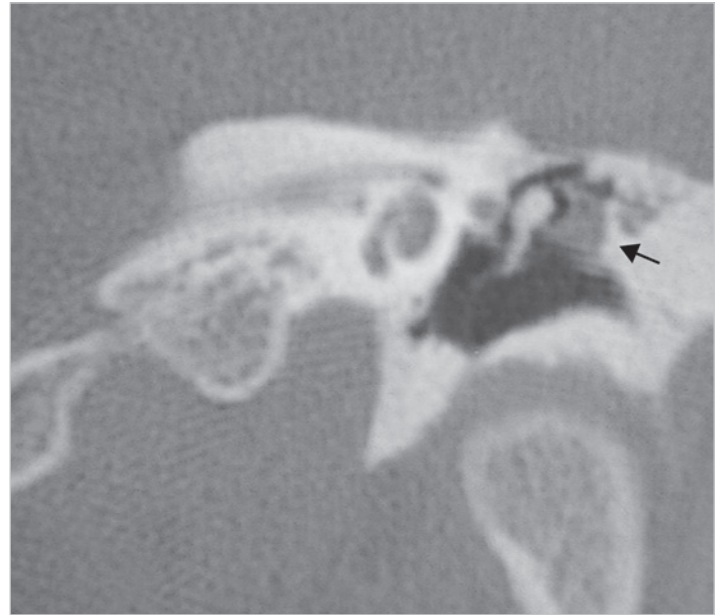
CT of the same case, coronal view. The cholesteatoma is limited in the epitympanic area (arrow), lateral to the head of the malleus. The mesotympanum is free of disease. The case can be a complete indication of modified Bondy technique.
